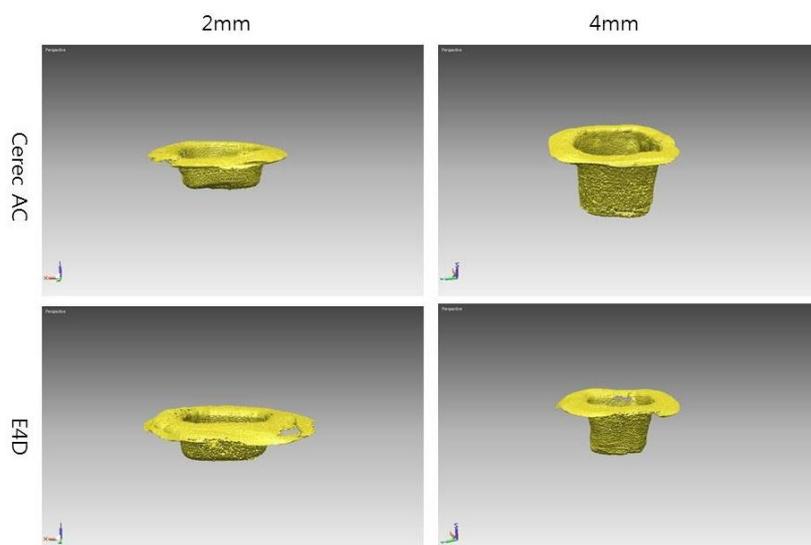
The designated area for the three dimensional reconstruction of gap volume on a CT file
